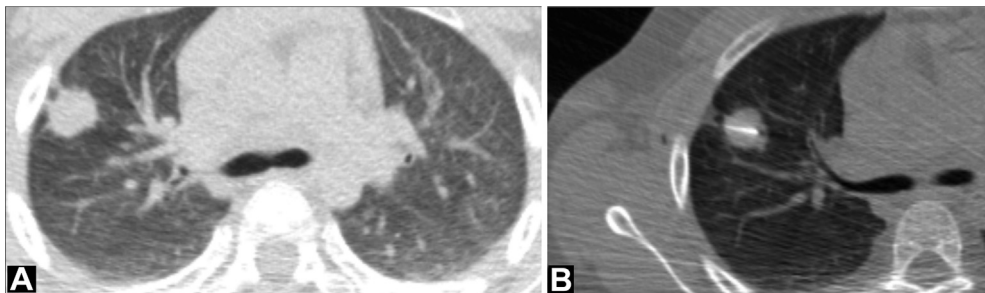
Axial CT image, lung window setting (A) shows a peripheral spiculated 3 cm mass in the anterior segment of the right upper lobe. Some pleural tails can be noted extending to the visceral pleura. Core needle biopsy of the lung nodule was performed under CT guidance (B). CT, computed tomography.
